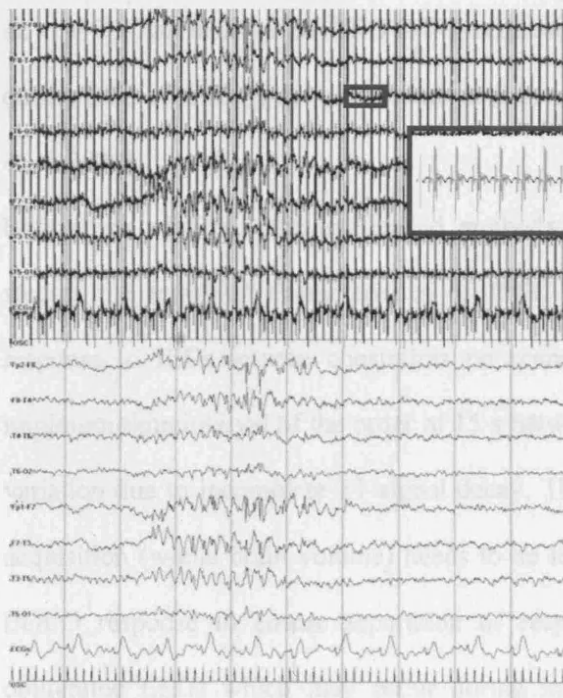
EEG acquired during echo planar MRI. Showing the large gradient artefact that effectively obliterates the EEG. Inset demonstrates that with a large dynamic range this artefact is measurable and after digital subtraction good quality EEG can be obtained.
